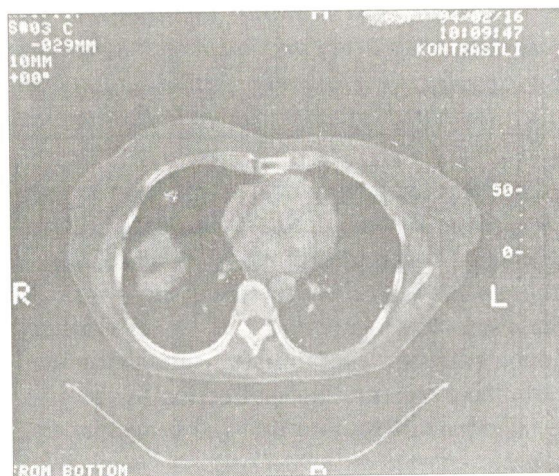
Computed tomography of the thorax shows the right lower lobe consolidation which is 4.5 cm in diameter and linear hypodense area presumably resembling the bronchial opening
